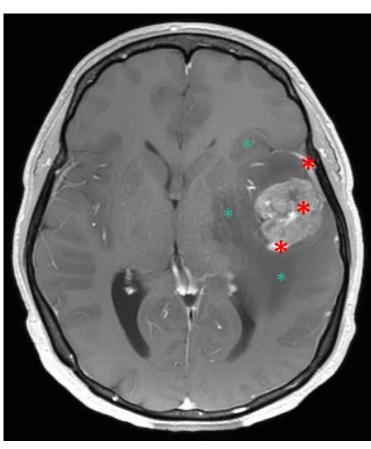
Contrast-enhanced T1-weighted image shows a glioblastoma with variable enhancement (red asterisks) surrounded by vasogenic oedema (green asterisks).
